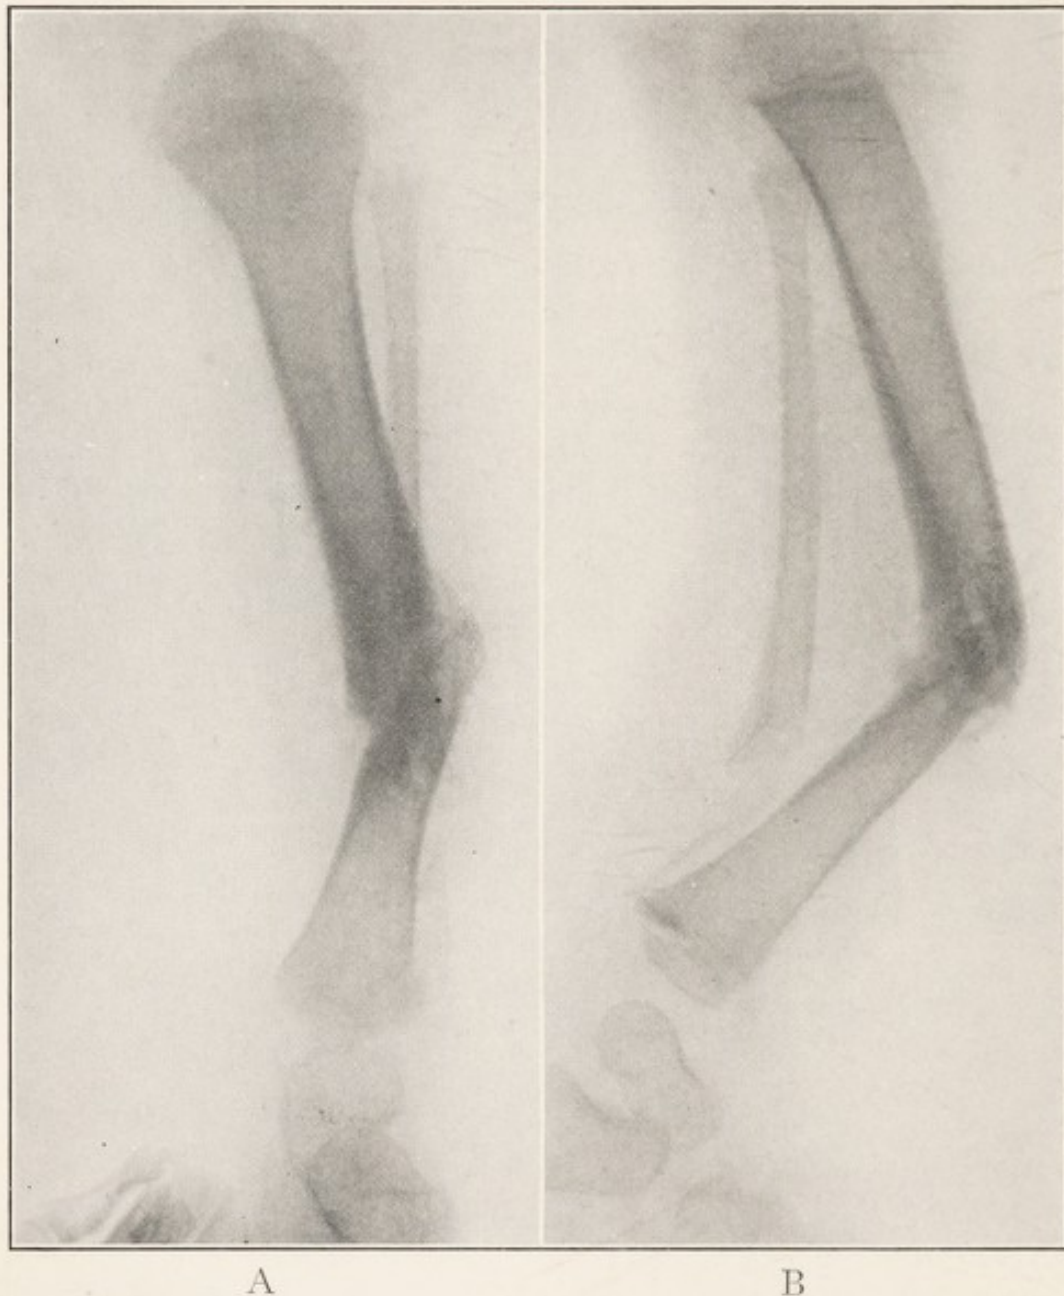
X-RAY SHOWING CONGENITAL FRACTURE OF TIBIA AND FIBULA, ANTEROPOSTERIOR VIEW.
